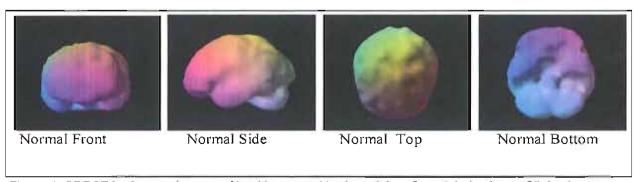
SPECT brain scan images of healthy normal brain activity. Copyright by Amen Clinics Inc. Printed with permission from MindWorks Press and Amen Clinics Inc.
